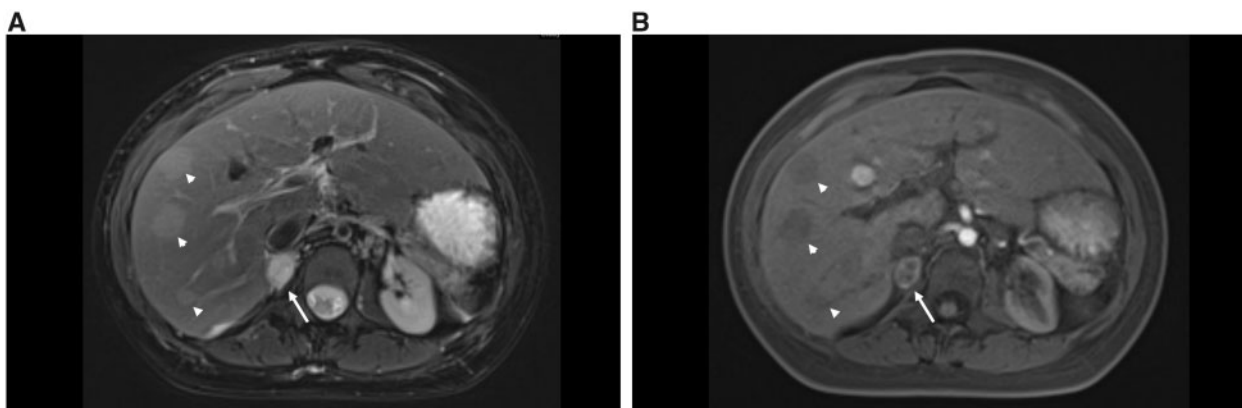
(A) T2 weighted fat saturated axial image from a magnetic resonance imaging abdomen scan which shows a hyperintense right adrenal nodule (arrow). The ovoid right hepatic lobe lesions are faintly hyperintense (arrowheads). (B) T1 weighted fat saturated post-contrast axial image from a magnetic resonance imaging abdomen which shows an arterially enhancing hyperintense right adrenal nodule (arrow). The ovoid right hepatic lobe lesions do not show arterial enhancement (arrowheads).
